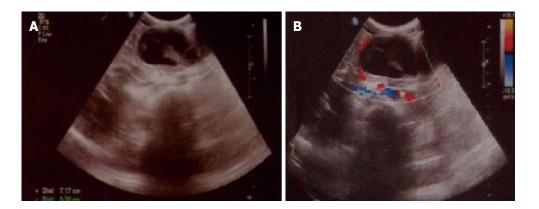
Abdominal ultrasonography demonstrated a solid cystic mass within the body of the pancreas. A: Ultrasonography showed a solid cystic mass within the body of the pancreas; B: Ultrasonography showed that the mass was surrounded by blood vessels.
